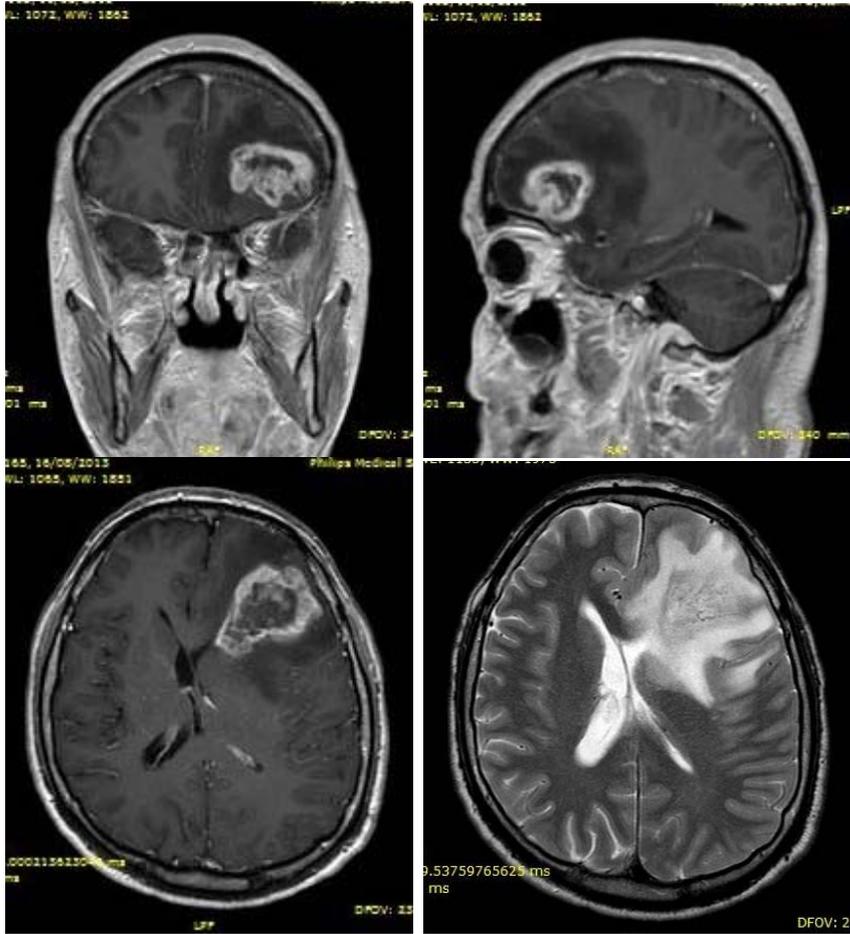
MRI-scan at the time of admission of the 48-year-old patient to the Department of Neurosurgery, showing a large tumor of the left frontal lobe. Prominent edema of the left frontal lobe can be observed on scan (D). (A) Coronal view. (B) Sagittal view. (C) Axial view. (D) Axial view T2 sequences. The neuro-oncology literature rarely reports on cases of aggression caused by a brain tumour. Few cases of unusual aggressive and antisocial behaviour have been correlated with glioblastoma involving left frontal lobe (Gilbert et al 2013).
